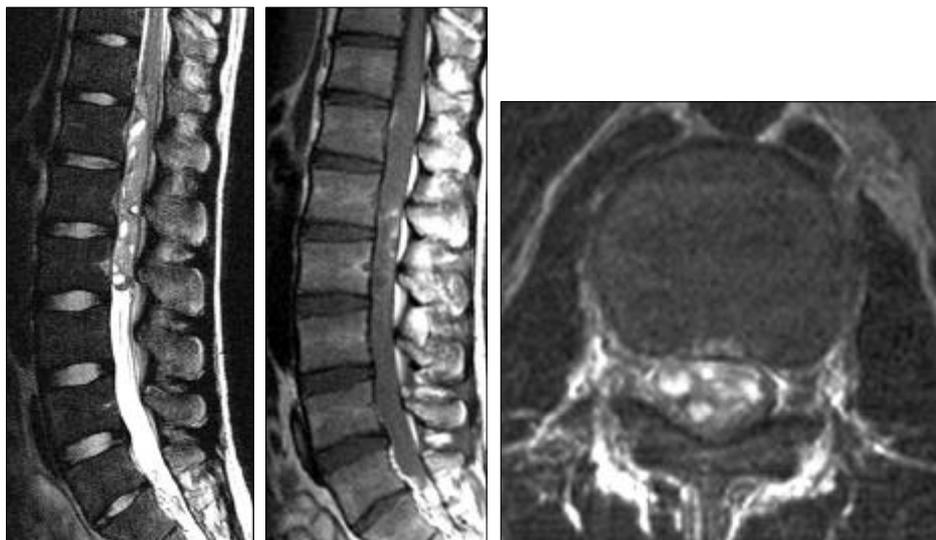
T2 weighted magnetic resonance image demonstrated an isosignal intramedullary mass, with multifocal high signal intensity, cyst like lesion. On T1 weighted magnetic resonance image, an isosignal intramedullary tumor, with strong enhancement, was demonstrated from the T11 to L2 level.
